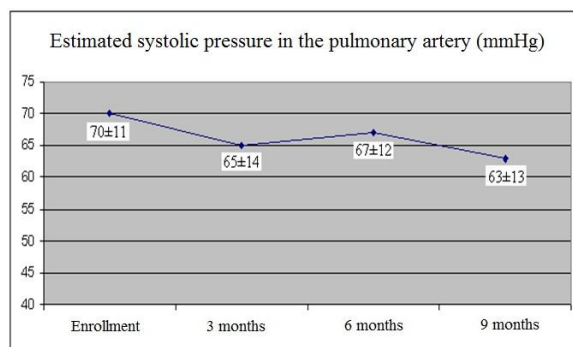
Evolution of SPPA, estimated by echocardiography, during the 9 months of monitoring.
